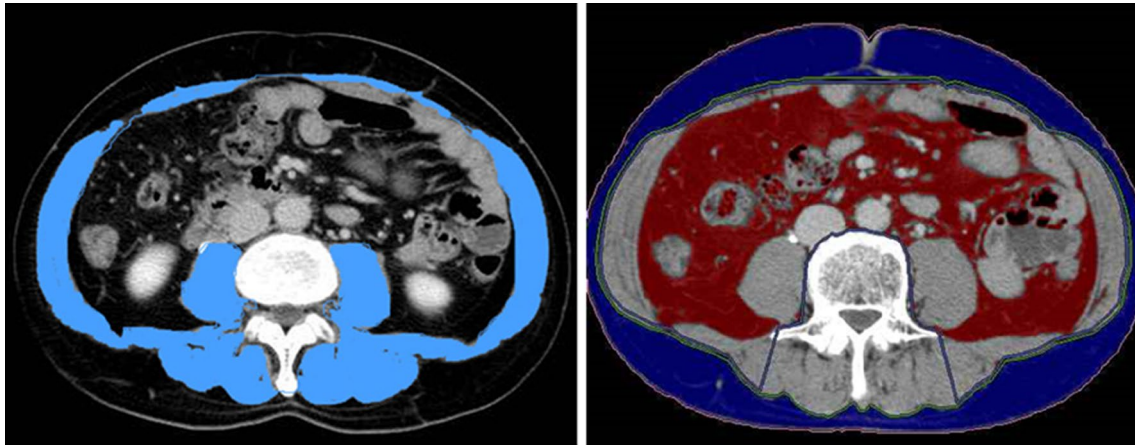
Computed tomogram shows area of skeletal muscle mass (highlighted *blue*) and visceral fat amount (highlighted *red*) in L3 region. Areas of skeletal muscle mass and visceral fat amount were measured using the Synapse Vincent system. Skeletal muscle was
